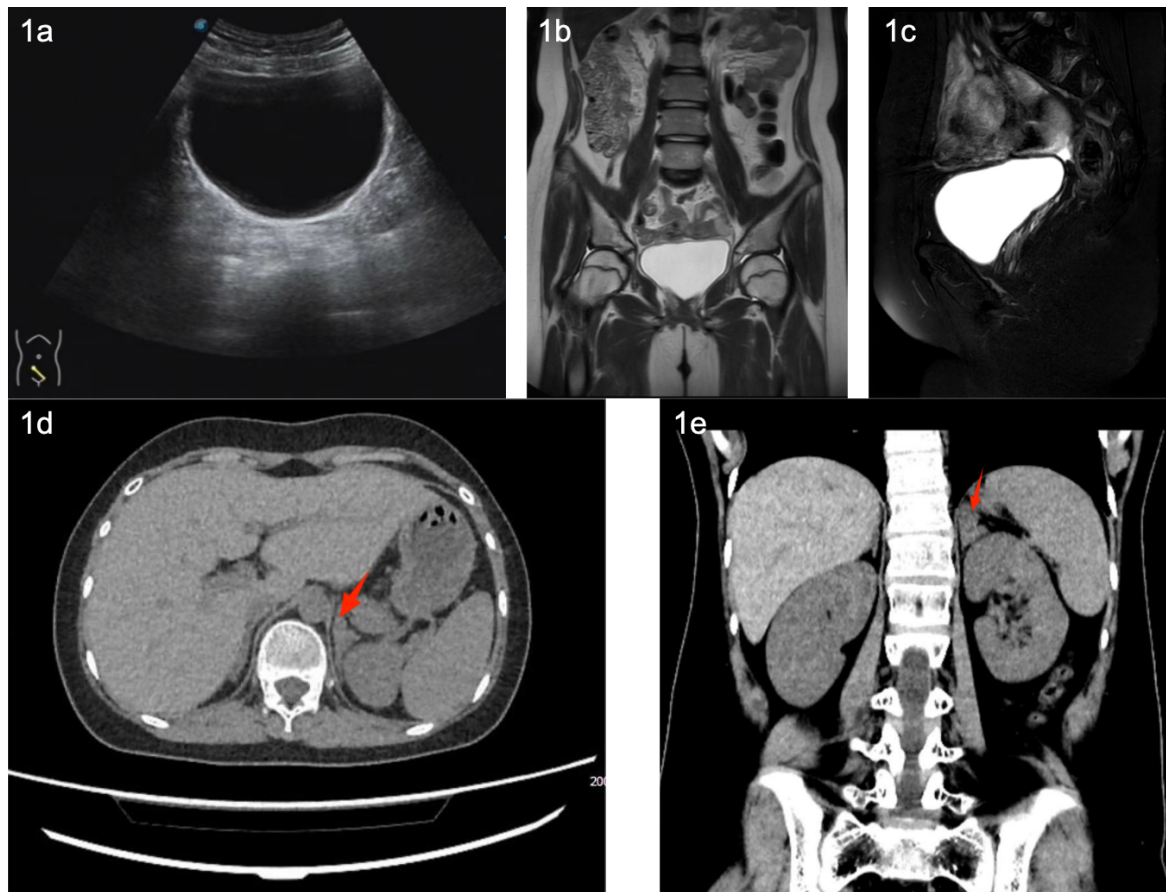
Patient's imaging examination. (a) Pelvic ultrasound. (b) T2W coronal image. (c) T2W sagittal image. (d) Adrenal CT sagittal image. (e) Adrenal CT coronal image demonstrating enlarged left adrenal glands with a space-occupying lesion in the left adrenal, about 41 mm × 14 mm, indicated via red arrow.
